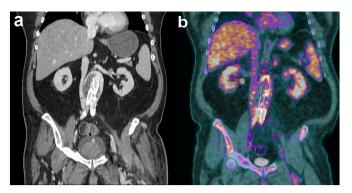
a) Contrast-enhanced CT. b) 18F-FDG-PET/CT fusion: coronal view of the aneurysm, showing high uptake on the lower neck of the aneurysm and milder uptake on the body and upper neck.
